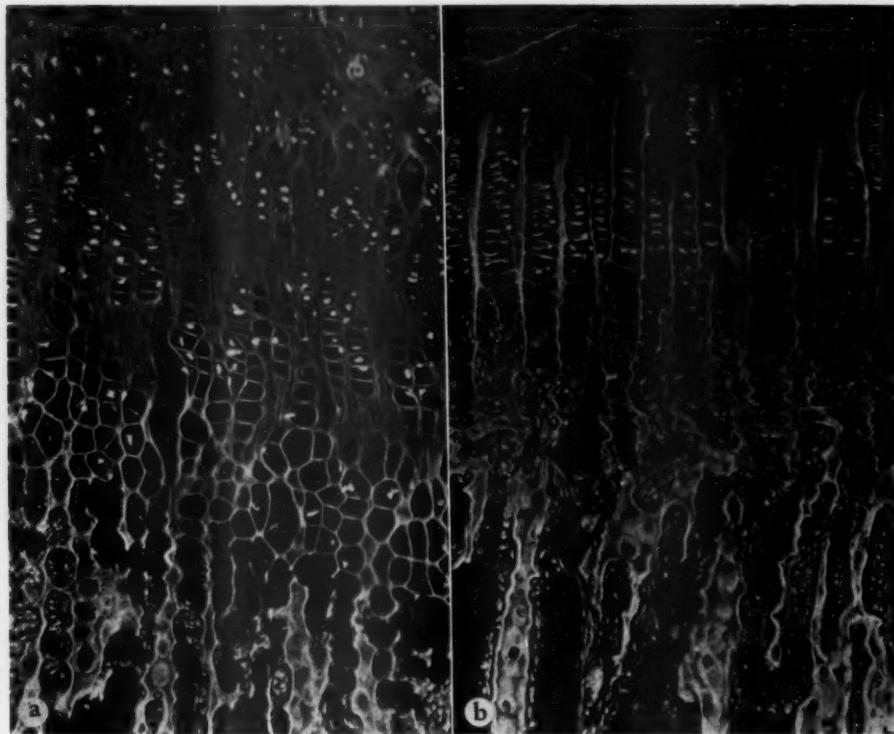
Soft-x-ray technique for determination of the dry weight. Epiphyseal growth zone of metatarsal bones.
